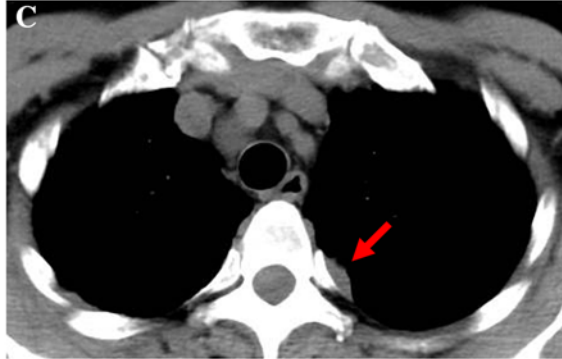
Chest CT on admission (a, b) and 2 months before admission (c, d). The size of the mass in the *upper-left* lobe increased rapidly over the course of 2 months (a, c). The size of the nodule in the *lower-left* lobe (12 mm) remained unchanged over the same period (b, d)
